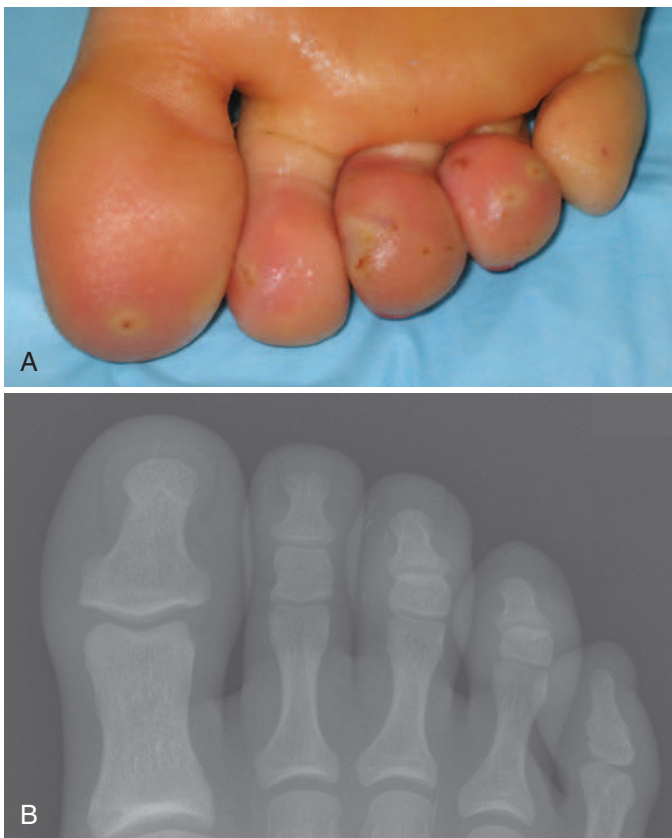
A, Crown-of-thorns starfish spine punctures to the toes. B, X-ray of foot of the same patient demonstrates retained spine fragments. (Courtesy Brian Lin, MD.)
